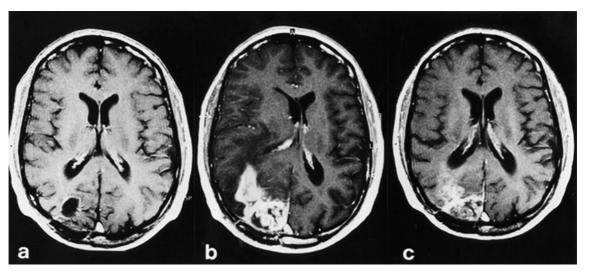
MRI scan of a 57-year-old study patient who underwent gtr (a). Fifty-three weeks after surgery, a large locoregional tumor relapse was diagnosed (b), which led to termination of TAM therapy. The tumor responded to TAM withdrawal by a remarkable tumor shrinkage documented by another MRI scan 5 weeks after TAM withdrawal (c). More details of this case are described in the text.
